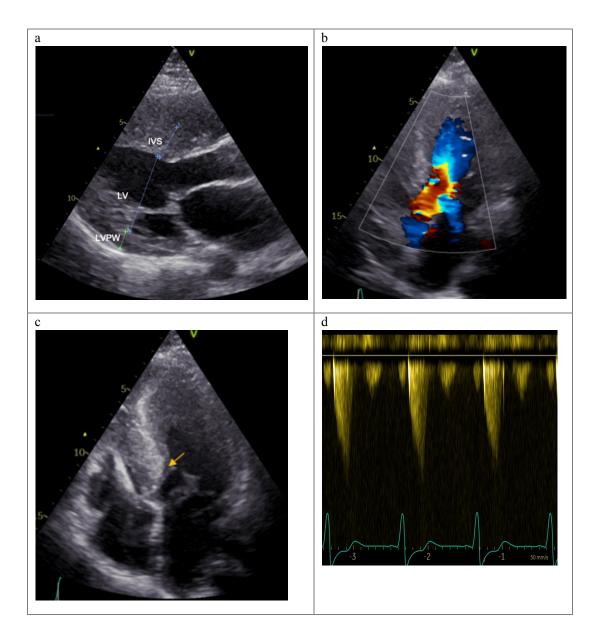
Echocardiogram pictures from a patient with HOCM
